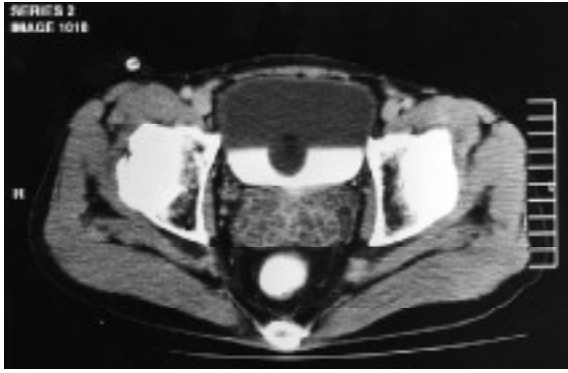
Another patient with acute bacterial prostatitis. Enhanced CT scan of the pelvis shows an inflamed prostate and early prostatic abscess formation.
